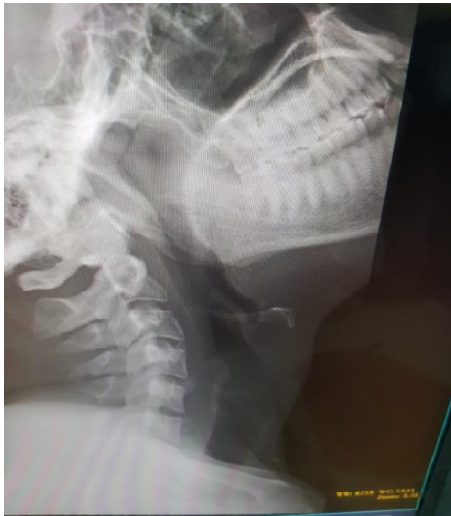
Showing normal radiograph of the lateral neck
